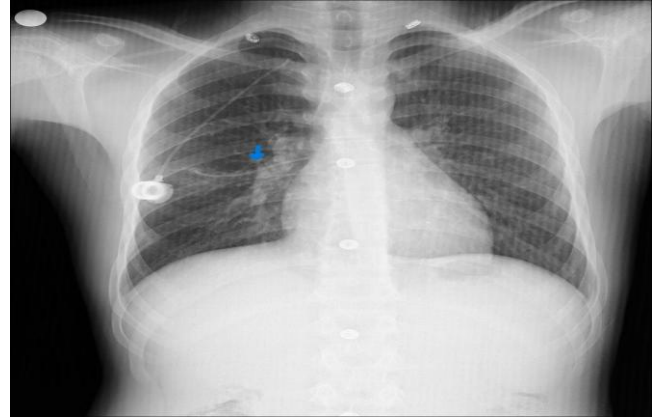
Chest radiography revealed a 7 cm linear opacity with a smooth border in the middle zone of the right lung
